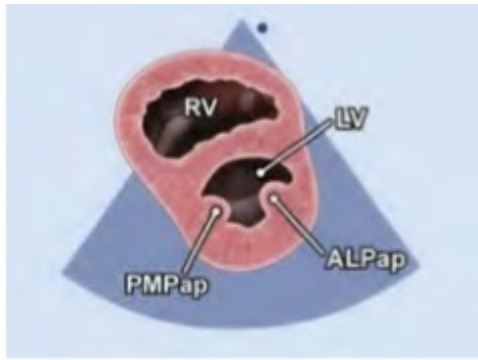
Parasternal short axis view of the left ventricle at the level of the papillary muscle. Reproduced with permission from the American Society of Echocardiography. (135)
